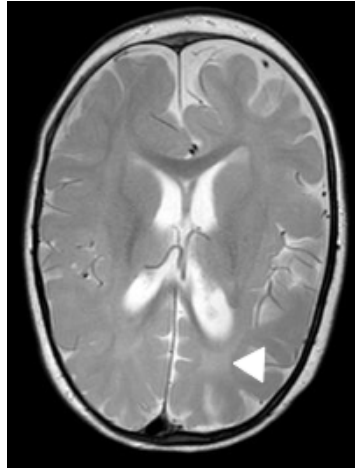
Axial T2 weighted MRI at 16 months of age. Relative hyperintensity of the deep white matter (white arrowhead) is suggestive of delayed myelination. Adapted from McTague et al, *Brain* 2013;136:1578-91.
